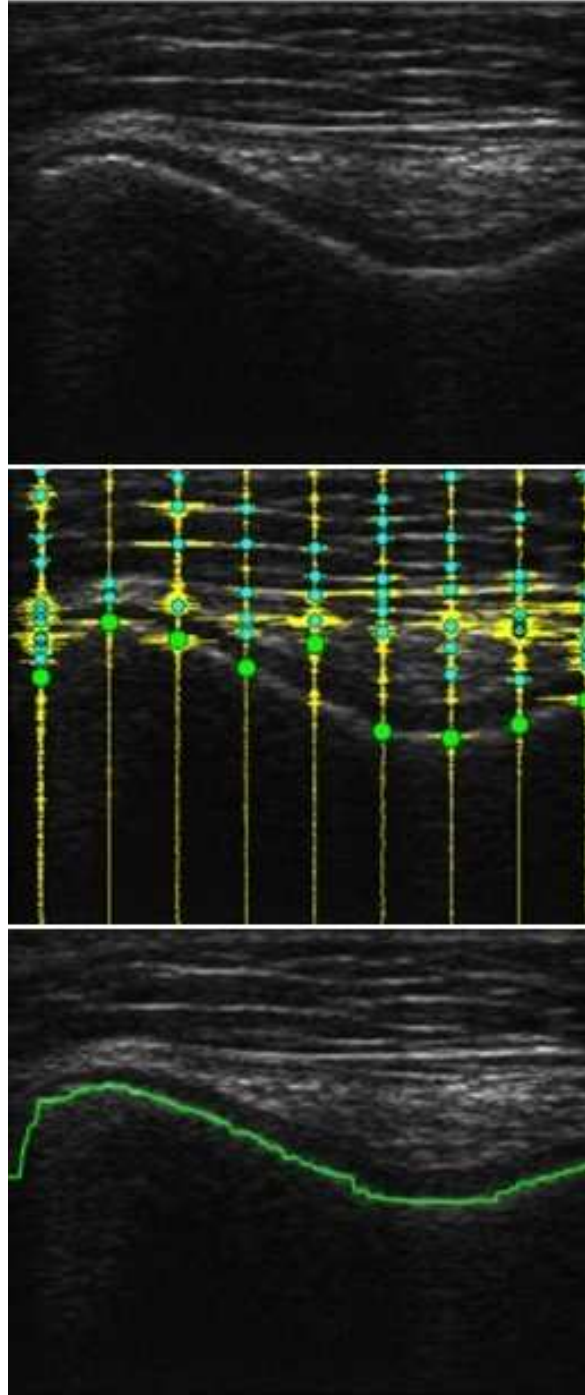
An ultrasound B-mode image of a cadaver's distal femoral groove (top), example ultrasound RF signals (middle), and the automatically extracted bone contour overlaid on the reconstructed B-mode image (bottom)
